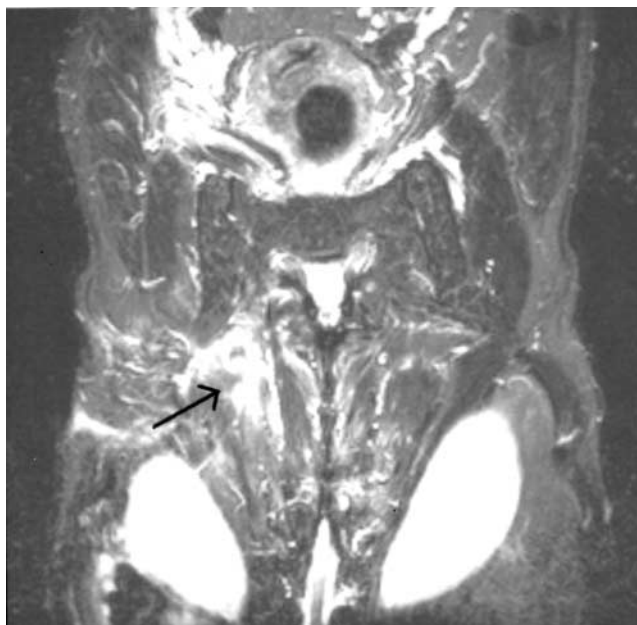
Coronal STIR MRI through posterior abdominal wall. High signal intensity lateral to left erector spinae muscles (arrow) indicates inflammation; however, this inflammation is not directly extending into the L5/S1 disc space
